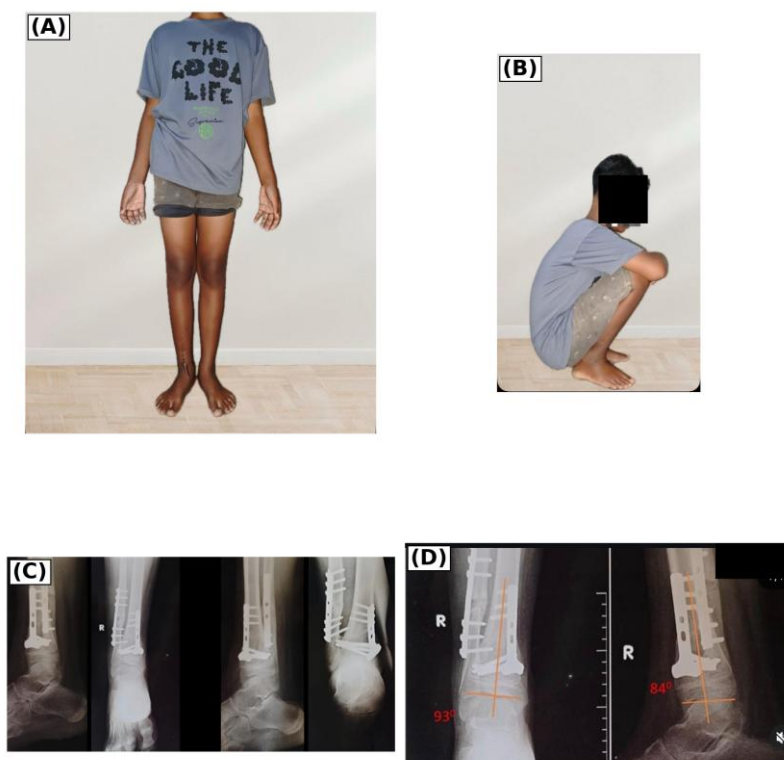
One-year clinical and radiographic follow-up. (A) Standing frontal clinical photograph showing restored limb alignment and a healed surgical scar. (B) Functional deep squat demonstrating improved, painless ankle motion (the patient's face has been masked to protect privacy). (C) Anteroposterior and lateral radiographs demonstrating bony union with maintained alignment. (D) Restored periarticular alignment with the tibial anterior surface angle corrected to 93.0° and the tibial lateral surface angle to 84.0°.
